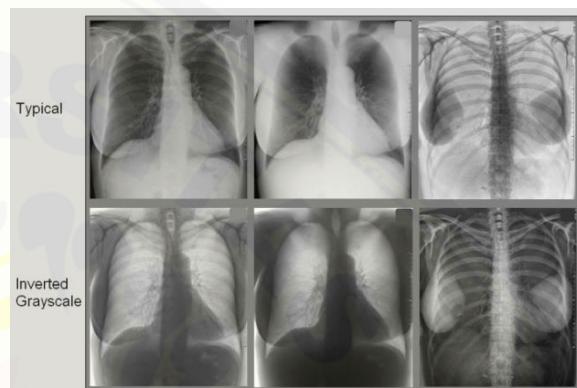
Chest radiography image with gray scale image processing (Source: UPSTADE Medical University, 2020)
